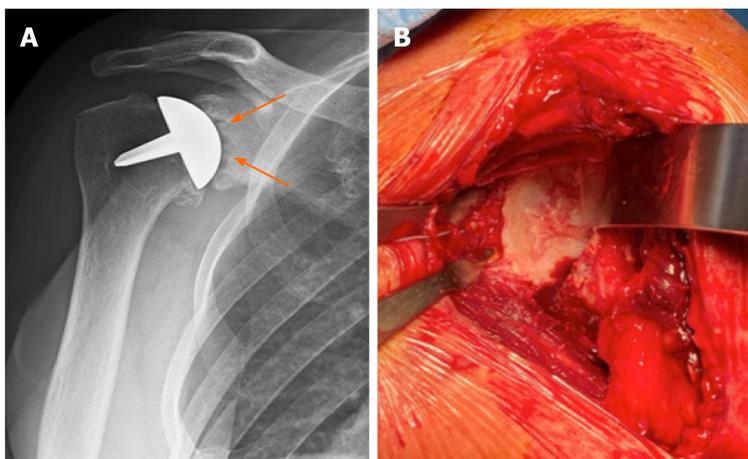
Patient 3. A: X-ray of the right shoulder. Anteroposterior view. An evident glenoid erosion (arrows) is detectable 5.5 yr after humeral head resurfacing; B: Revision surgery. Deltopectoral approach. After removal of the implant the glenoid surface damage was assessed by retracting the humerus.
